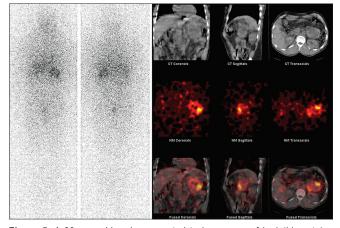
A 30-year-old male suspected to be a case of hydatid cyst (on ultrasonography) in the tail of pancreas developed accelerated hypertension upon handling of the mass inside the operation theatre. Surgery was abandoned. Iodine-131 metaiodobenzyl guanidine (MIBG) whole body scintigraphy and single photon emission computed tomography/computerized tomography performed showed MIBG avidity in the mass. Patient was subjected to repeat surgery and was proven to have neuro-endocrine tumor post operatively
